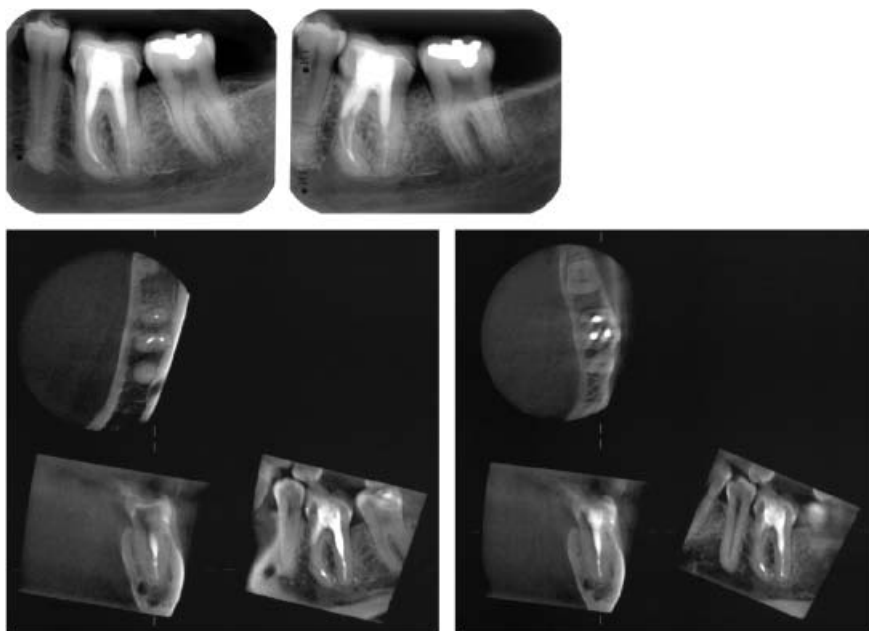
Periapical radiographs show little more than a diffuse periodontal ligament space at the upper distal surface of the first molar. Limited cone beam computed tomography slices reveal an oblique root fracture in the distal root with associated inflammatory reaction, a post in the mesio-buccal root adjacent to its surface, and root-canal filling material deposited in the upper part of the mandibular canal. The fracture was confirmed at surgery.
